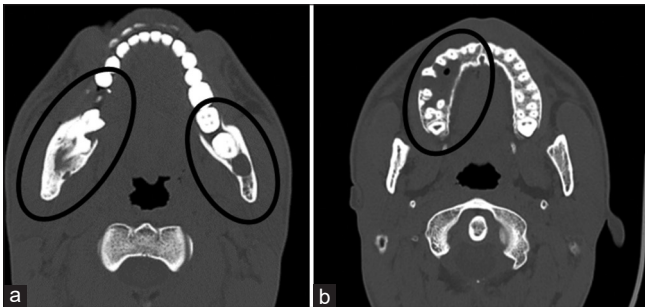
Computed tomography – axial sections of facial bones. (a) Well-defined unilocular homogeneously hypodense lesions on the right and left sides of the mandible with impacted 47, 48, and 38, respectively. (b) Unicystic appearance from the right maxillary posterior teeth region
